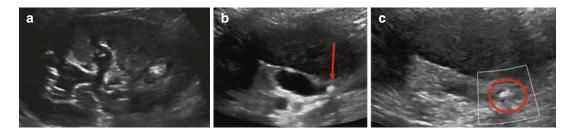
Ultrasound shows kidney with hydronephrosis (a). Hyperechoic focus with sharp posterior shadowing is lodged at the ureteropelvic junction (b, red arrow). On Doppler (c), there is posterior twinkling artifact (red circle)
